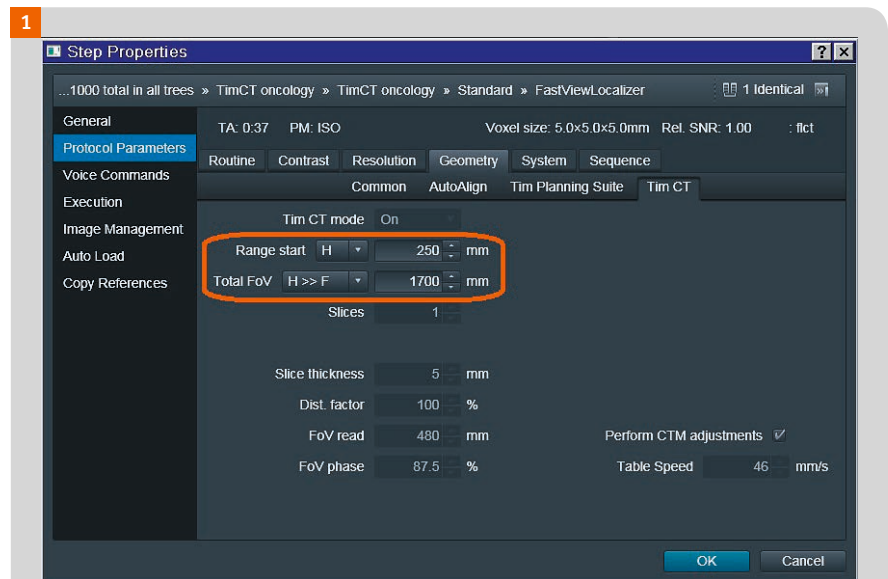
FastView parameter card: Geometry > Tim CT
